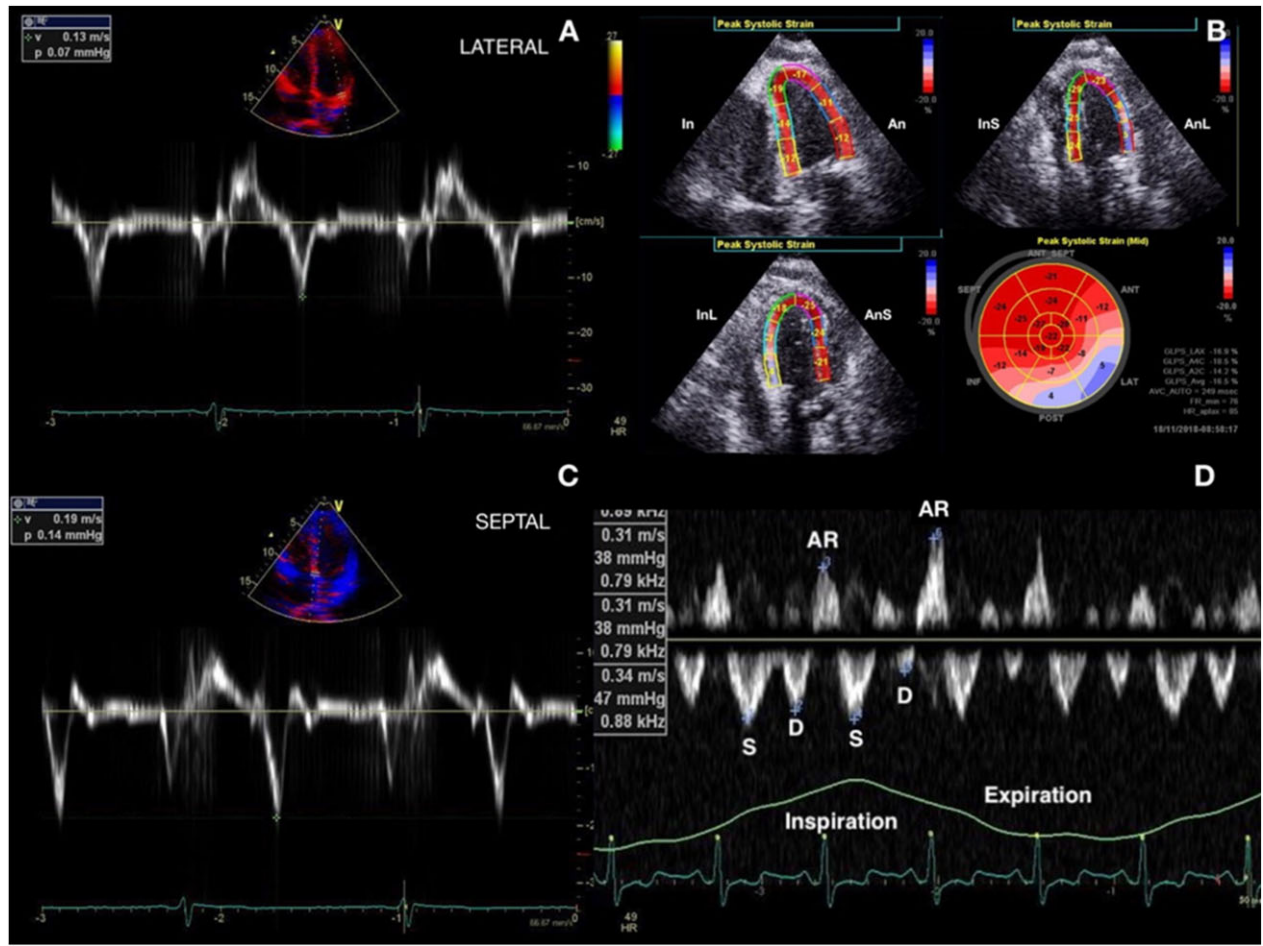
(A) Tissue Doppler velocity of the lateral mitral annular diastolic velocity (e' of 13 cm/s) and (C) tissue Doppler velocity of the septal mitral annular diastolic velocity (e' of 19 cm/s) demonstrating 'annulus reversus'. (D) Pulsed-wave Doppler of the hepatic veins with an end-diastolic reversal velocity of 0.34 m/s and a forward velocity of 0.31 m/s on expiration (ratio of 0.91). (B) Decreased peak LV longitudinal strain of the lateral wall from tethering with an increase in the septal peak longitudinal strain demonstrating 'strain reversus'. In, inferior; An, anterior; InS, infero-septal; AnL, anterolateral; InL, inferolateral; AnS, anteroseptal; S, systolic; D, diastolic; AR, atrial contraction-induced reversal.
